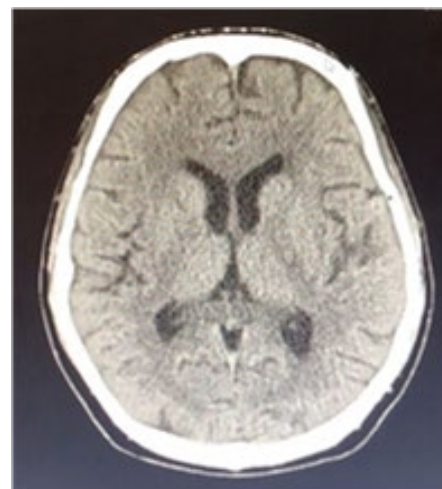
Cranial CT scan of the patient showing mild cerebral atrophy for a 34-year-old
